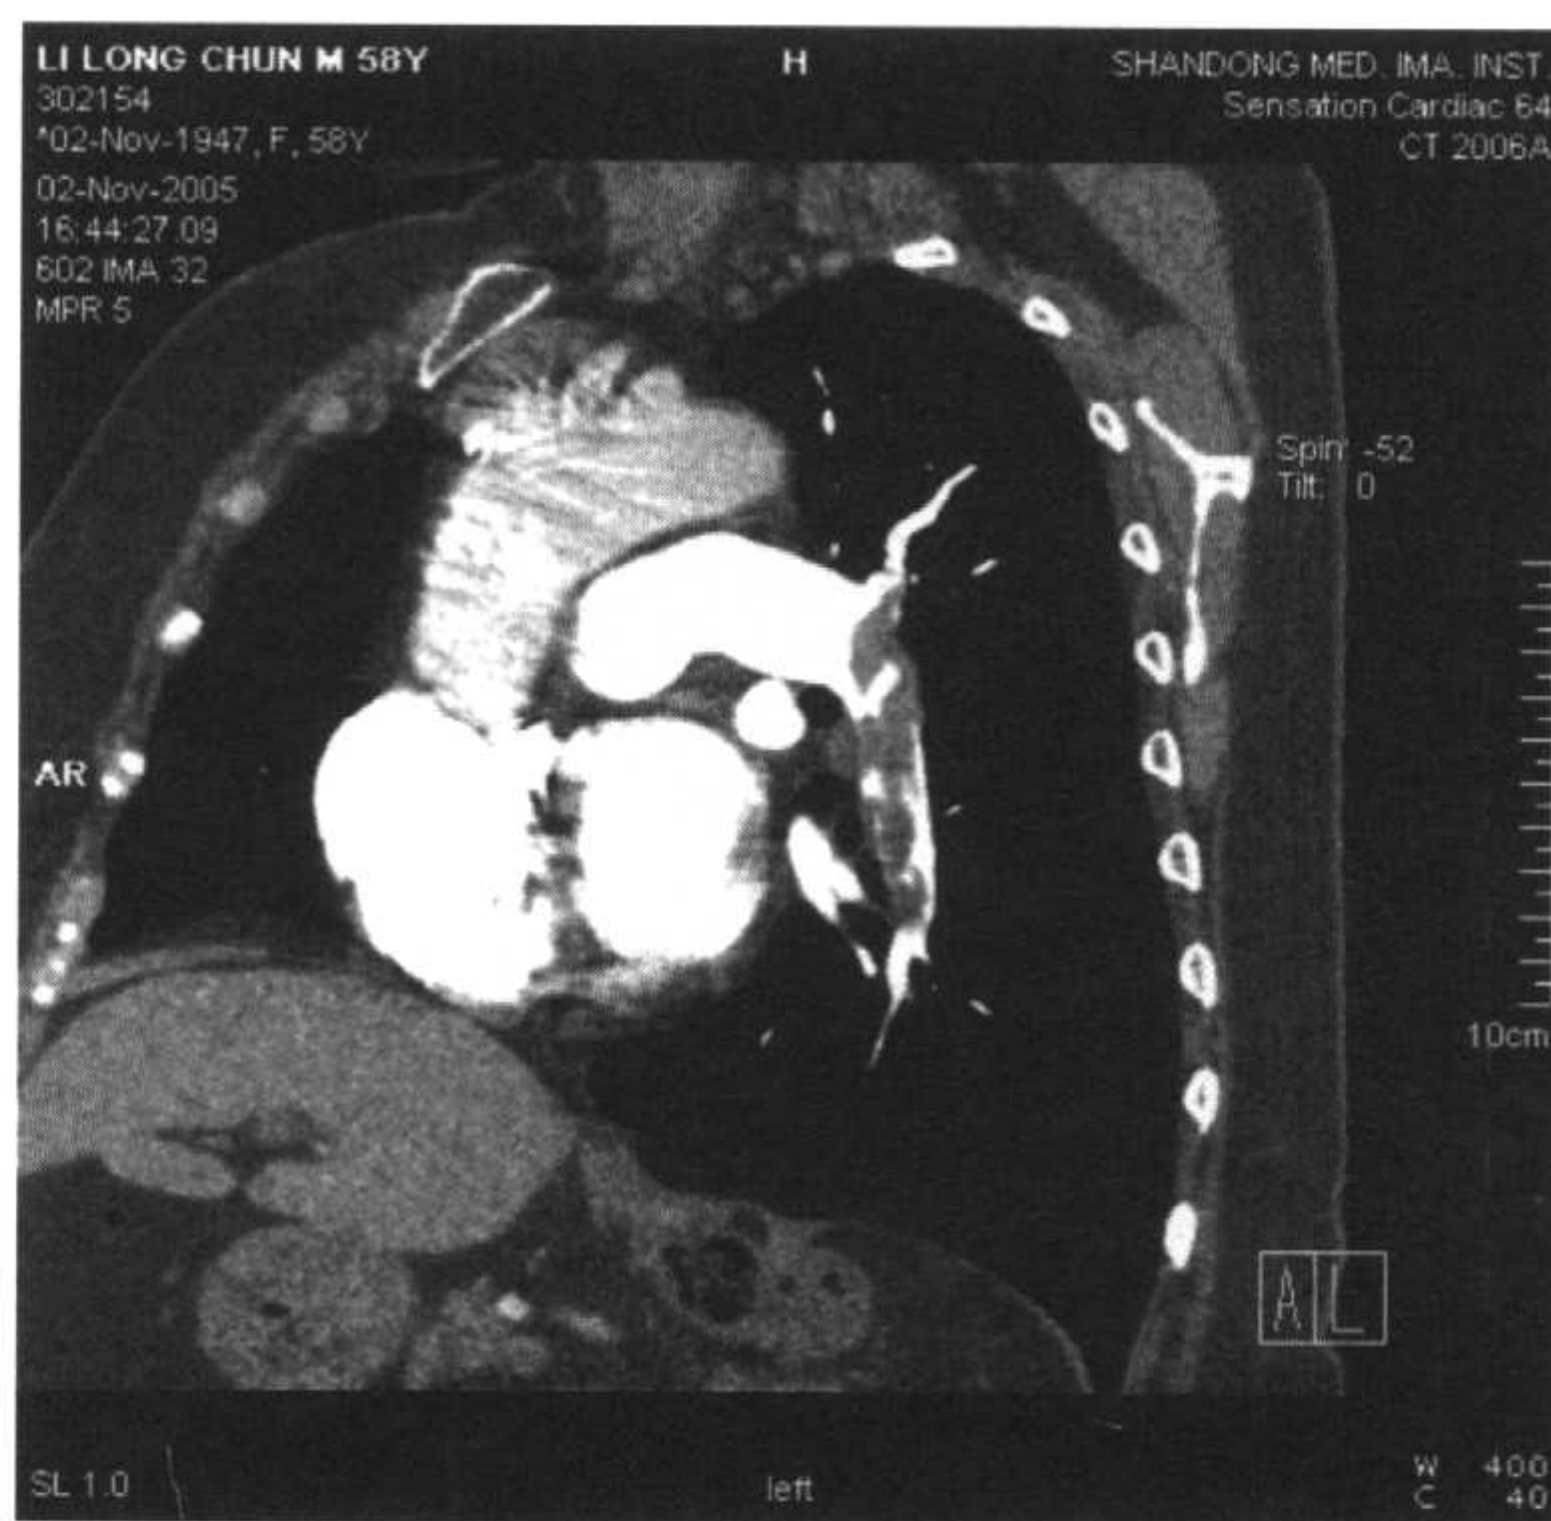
126 肺动脉 CTA 矢状面 MPR 图像
